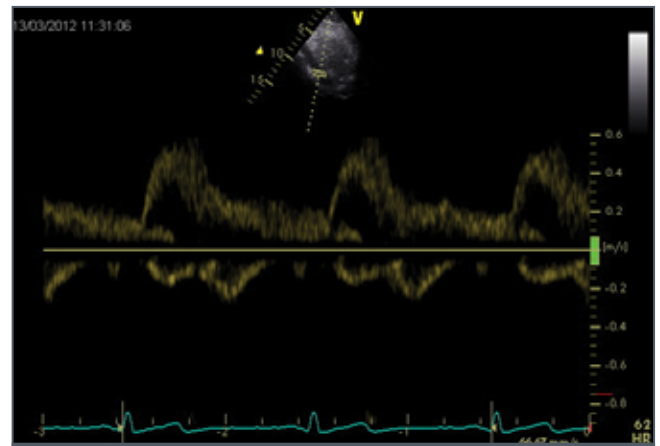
PW Doppler in the abdominal aorta acquired subcostally.
